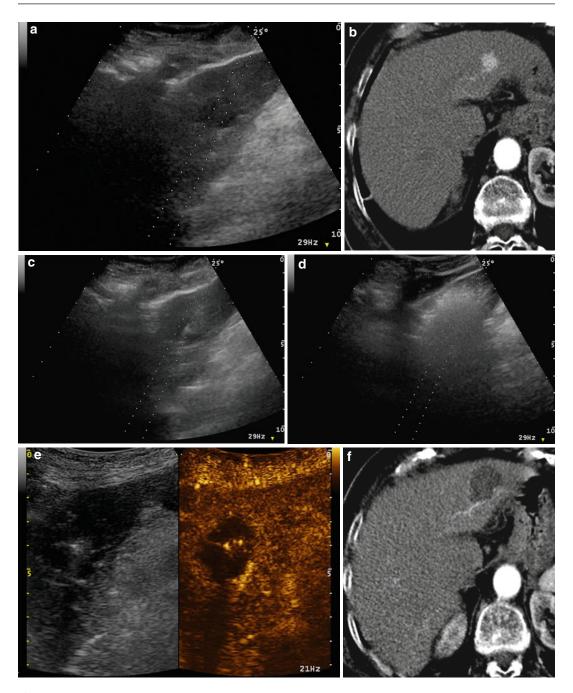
1.9-cm HCC in the left hepatic lobe, seen on B-mode US (a) and contrast-enhanced CT in arterial phase (b) and precisely targeted with US guidance (c). A wide cloud of gas bubbles is seen on US during ablation (d).
